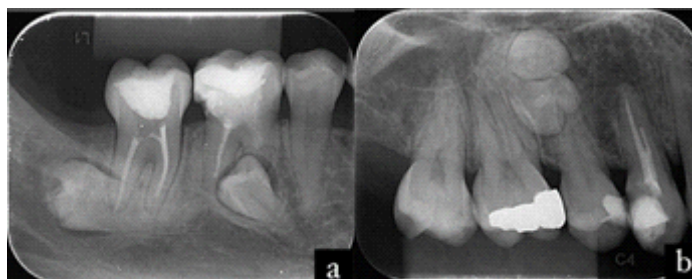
Periapical radiographs: (a) elements 46 and 47 filled, mesial root of 46 filled with MTA; (b) proximity of the supra to the root of 15.
